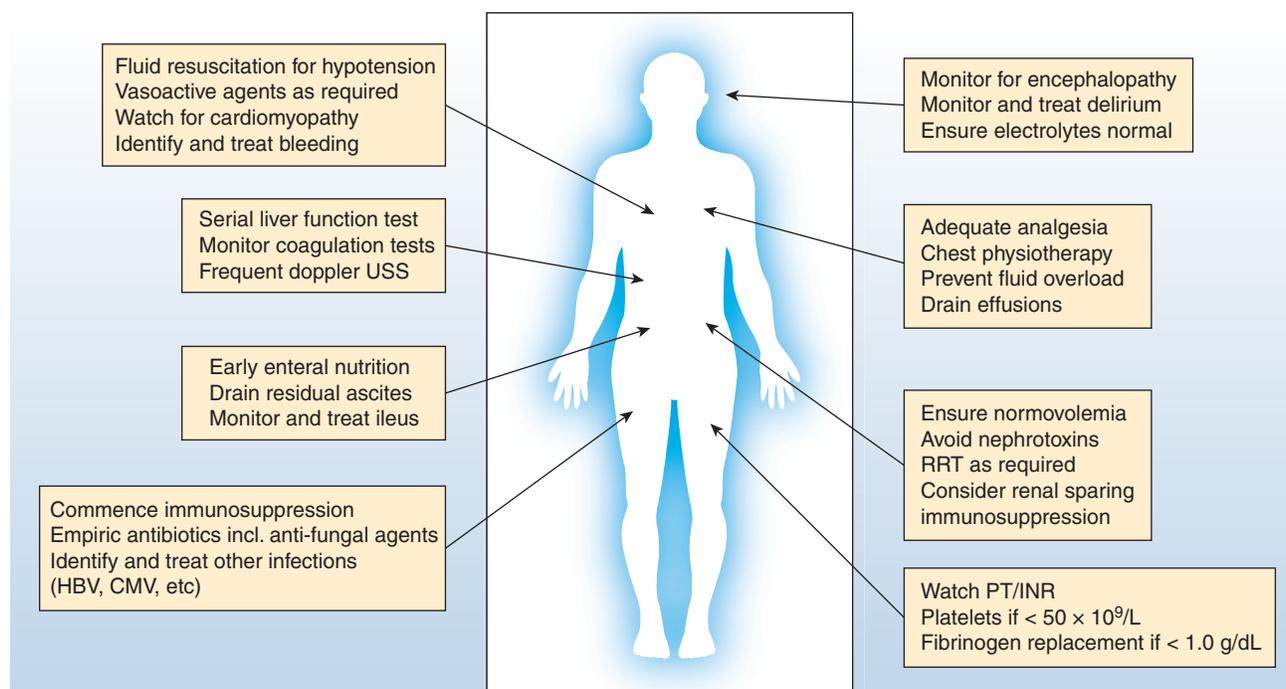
Systematic approach to critical care after liver transplant. CMV, Cytomegalovirus; HBV, hepatitis B virus; INR, international normalized ratio; PT, prothrombin time; RRT, renal replacement therapy; USS, ultrasound.
